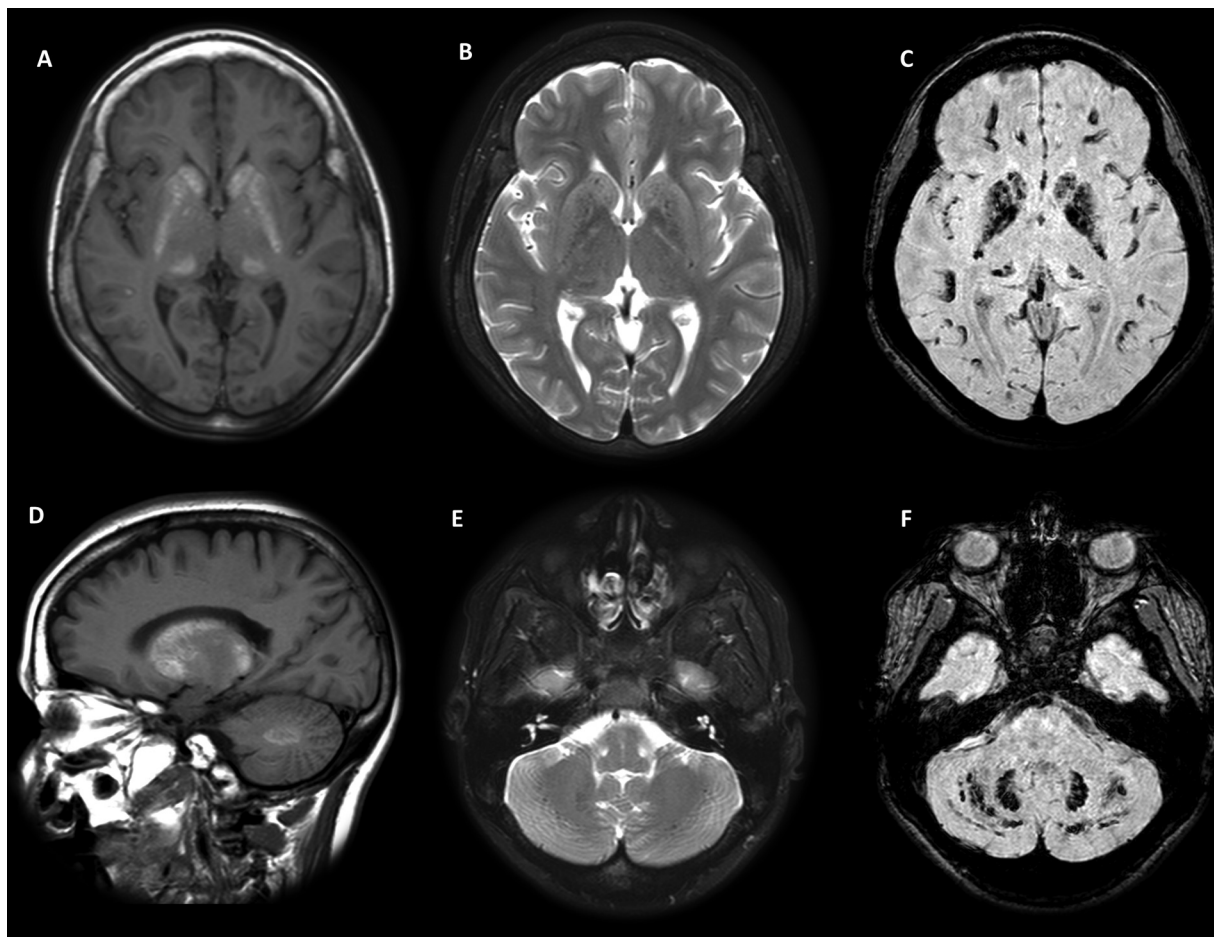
Brain MRI: A/D - T1 hyperintense signal in the basal ganglia and dentate nuclei; B/E - T2 low to isointense signal in the basal ganglia and dentate nuclei; C/F - SWI hyposignal in the basal ganglia, dentate nuclei and subcortical white matter.
